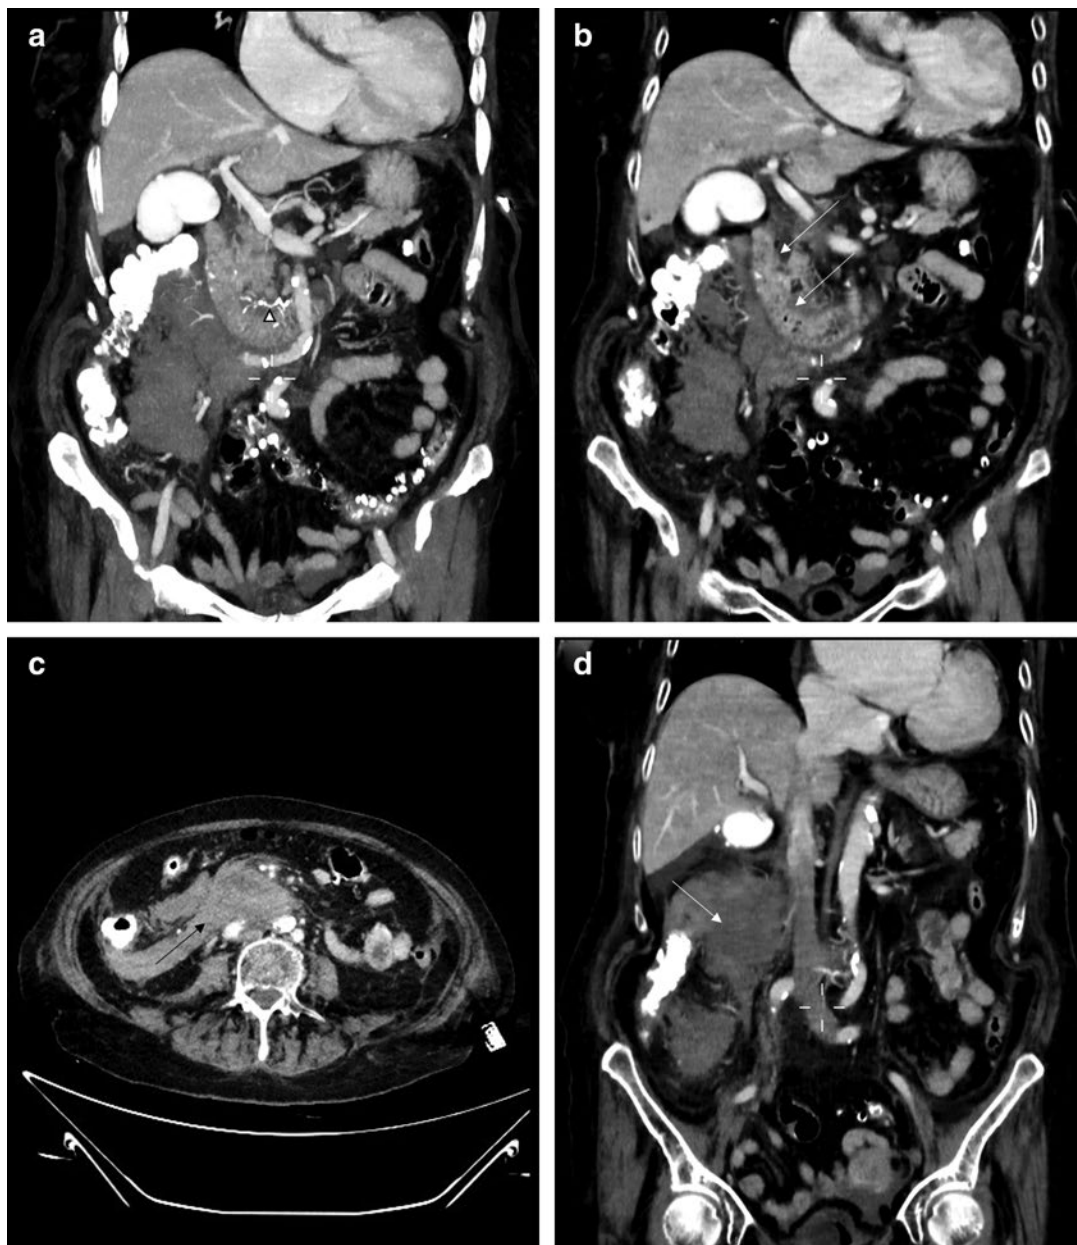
Coronal computed tomography (CT) of the abdomen showing the Glubran used for the pseudoaneurysm embolization (arrowhead; a), with no signs of ischemia of the duodenal walls (arrows; b). CT of the abdomen showing a huge reduction of the peritoneal hematoma in axial (arrow in c) and coronal (arrow in d) planes when compared with those in images in Figure 1e, f.
